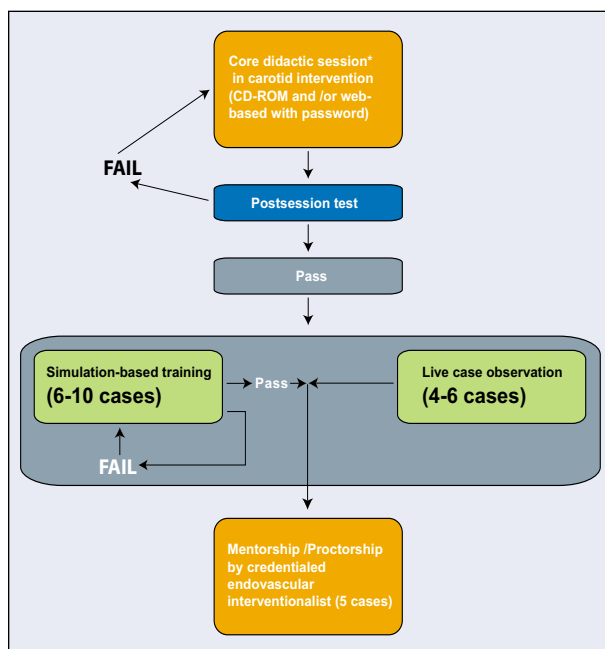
Algorithm for training in endovascular intervention of carotid arteries in anticipation of FDA approval of high-risk carotid intervention. *Core didactic session should include training on patient selection strategy and noninvasive carotid imaging such as carotid Doppler ultrasound (proposed by Daniel McCormick, DO).
